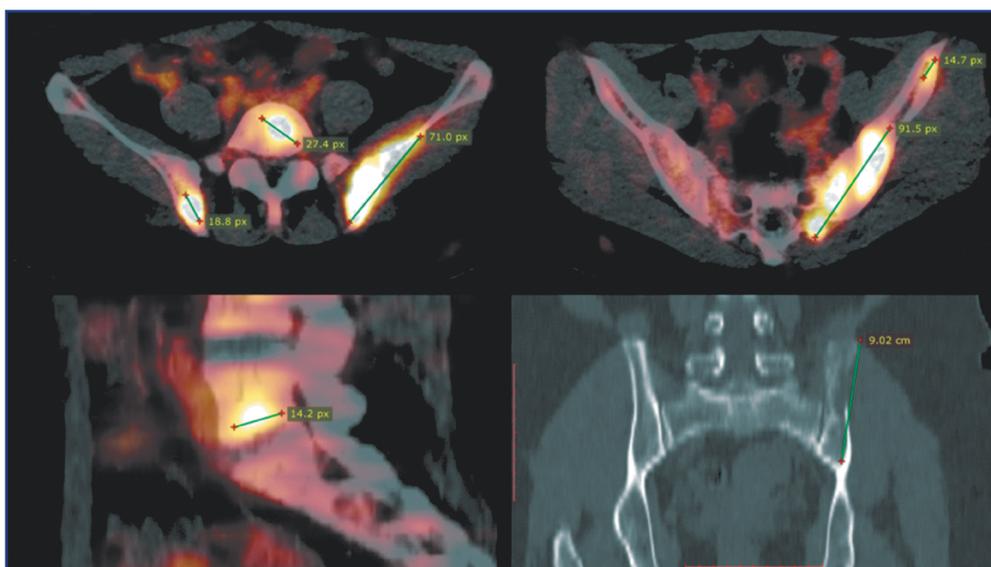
PET/CT. Metastasis lesion of the L5 vertebra, pelvic bones.
